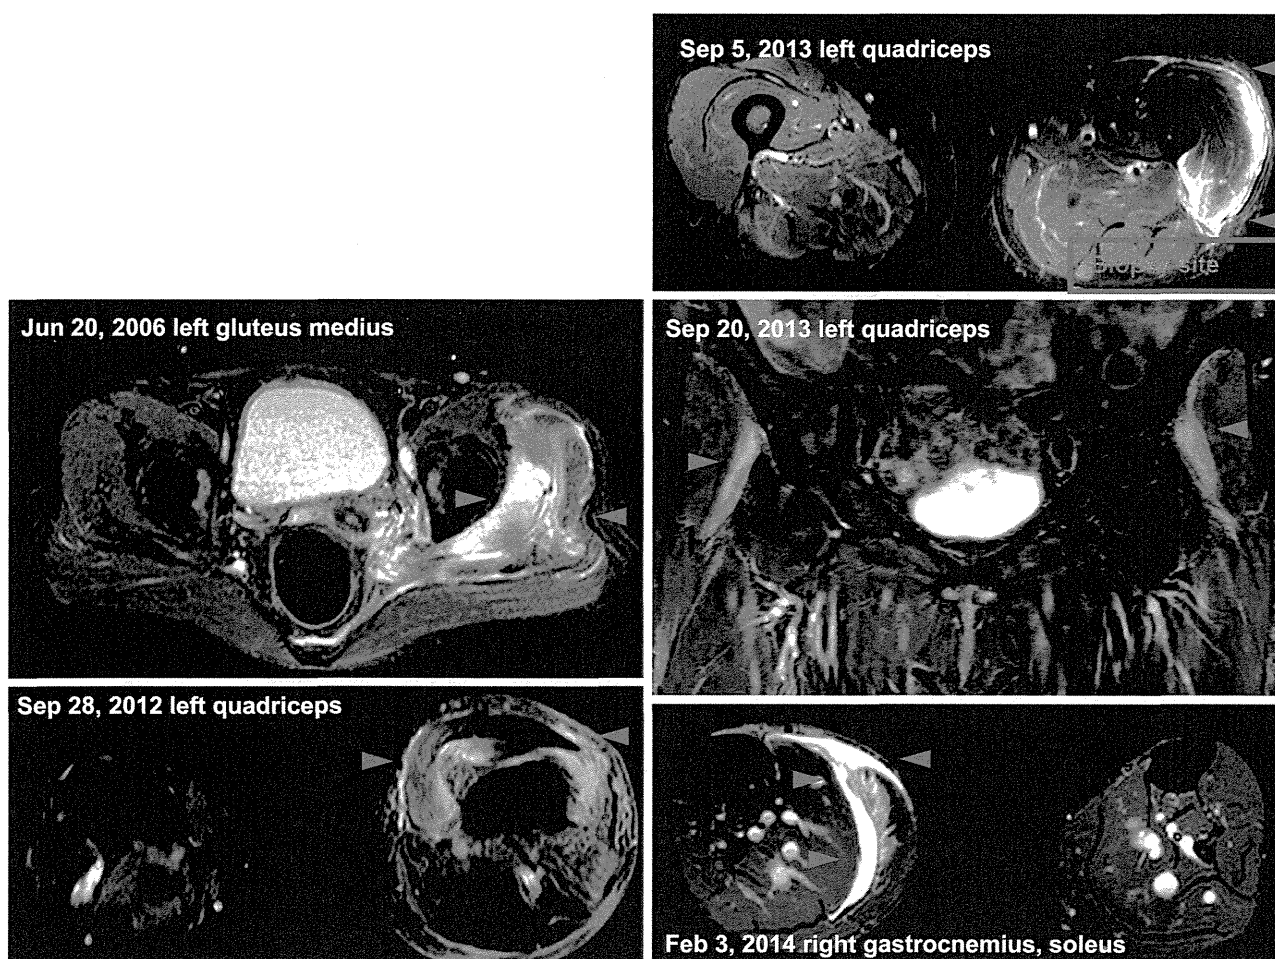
Magnetic resonance imaging (short TI inversion recovery) of the lower limbs of the patient. High intensity of fascia and muscle appeared in different sites in each attack.
